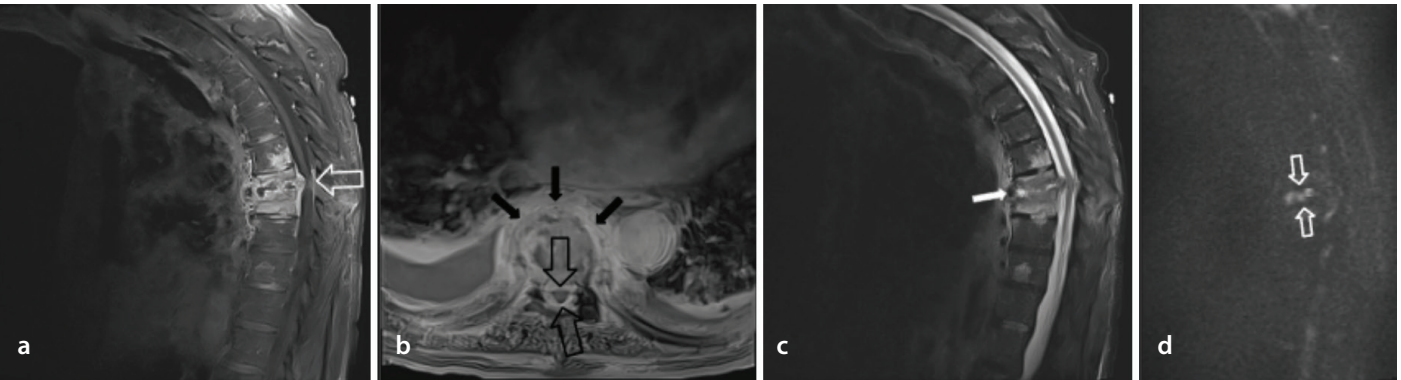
Magnetic resonance imaging features of spondylodiscitis. (a) Sagittal post-contrast fat-saturated T1-weighted image of the thoracic spine showing endplate erosions, diffuse enhancement throughout the adjacent vertebral bodies, peripheral enhancement around the infected disc material, epidural thickening, and enhancement (white-outlined arrow). (b) Axial fat-saturated post-contrast T1-weighted image of the thoracic spine showing paravertebral soft tissue thickening and enhancement (solid black arrows), and epidural thickening and enhancement (black-outlined arrows). (c) Sagittal short tau inversion recovery image of the thoracic spine showing fluid signal in the disc (solid white arrow). (d) Sagittal diffusion weighted image (DWI) of the thoracic spine showing restricted diffusion in the disc and endplates (white-outlined arrows) (not the “claw sign,” which demonstrates increased signal on DWI in the endplates but not in the disc). There is corresponding hypointense signal on the apparent diffusion coefficient map (not included).
